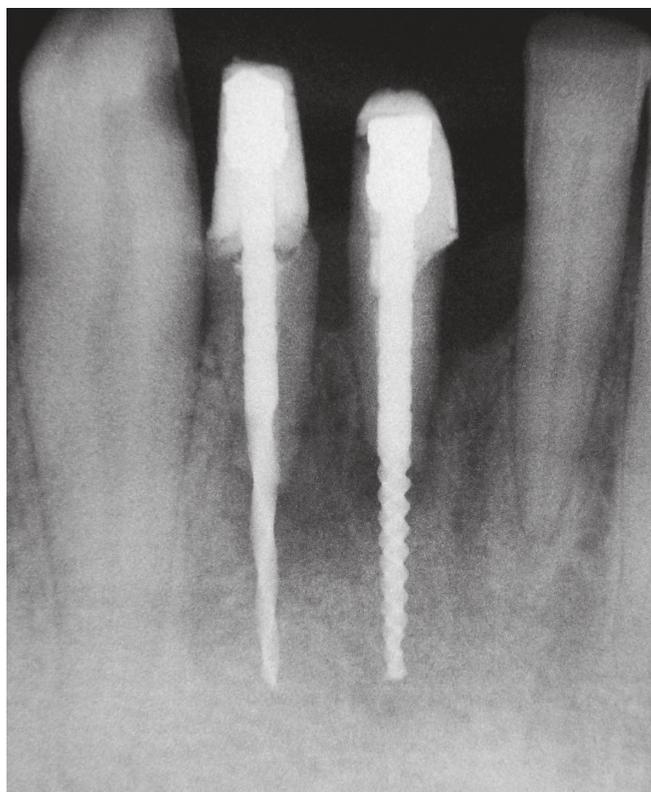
Radiographic preservation after 16 months of stabilization of elements 31 and 32.
